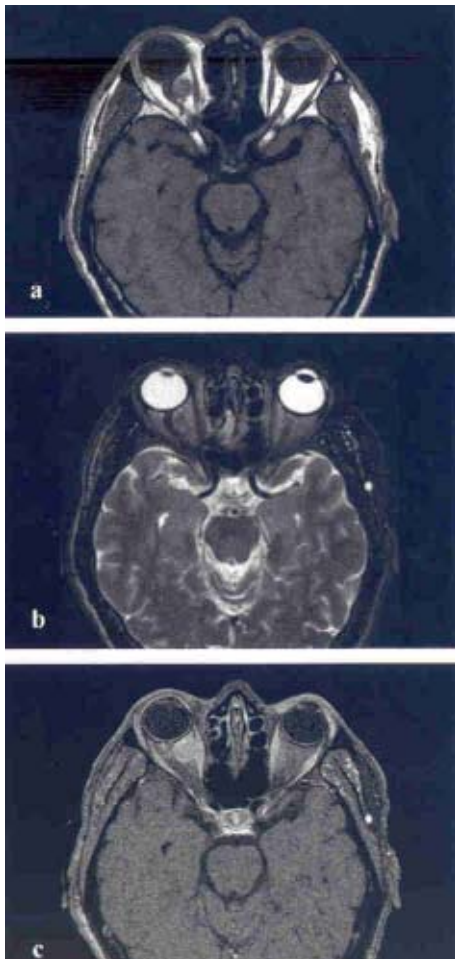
(a) T1 weighted MRI scan, (b) T2 weighted MRI scan, (c) contrast MRI scan. The scans showed an intraconal mass displacing the right optic nerve laterally. The mass appeared heterogenous with contrast.
